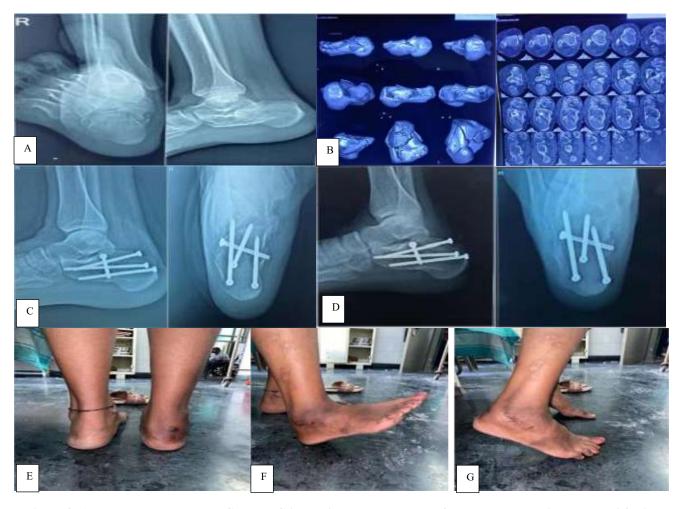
A-pre op x-ray, B-pre op CT scan, C-immediate post op x-ray, D-follow up, E-heel width, F-Dorsi flexion and G-planter flexion.
